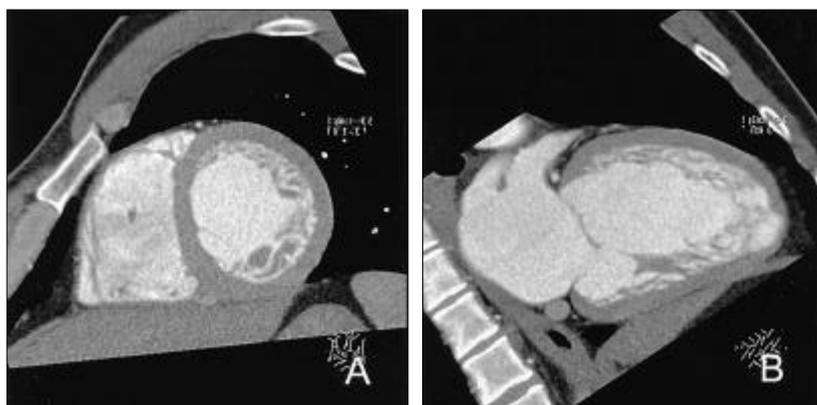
Multidetector computed tomography (MD CT) of the proband. (A) Post-contrast coronal computed tomography (CT) section at the level of apex to mid-portion of the left ventricle shows thick left ventricular wall with an inhomogeneous appearance, multiple prominent muscular trabeculations and deep intertrabecular recesses. (B) Postcontrast midsagittal CT section shows a peculiar appearance characterized by the presence of numerous separated bands inserting into the anterior wall near the apex.
